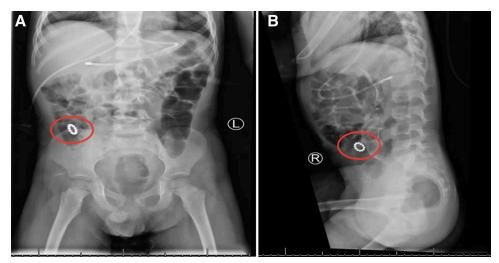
A) Supine AP abdominal radiographic imaging revealing the 17.4 mm diameter ring of 12 magnetic beads in the RLQ (each ring measuring about 3.3 mm); B) Lateral view of the abdomen, confirming the location in the RLQs. RLQ = right lower quadrant.
